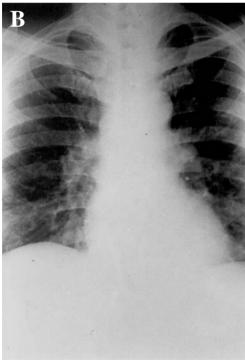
(A) Chest X-ray showing multiple pulmonary metastases before androgen deprivation therapy. (B) Complete resolution after androgen deprivation therapy.
